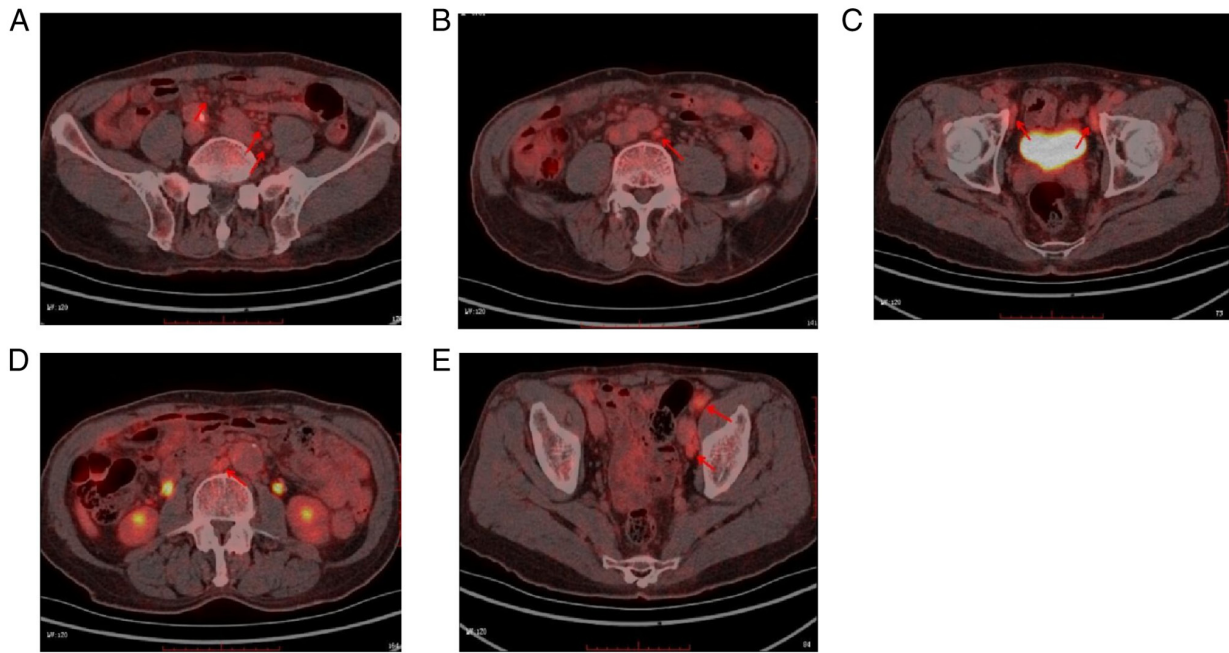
Whole body PET-CT. (A-E) PET-CT demonstrated abnormally increased ^{18}F -fluorodeoxyglucose metabolism in lymph nodes in numerous regions of the body, which was consistent with the metabolic changes in progressive disease stage after lymphoma treatment. PET-CT, positron emission tomography-computed tomography. (A) Pelvic plane (S2). (B) Abdominal plane (L1-L2). (C) Pelvic plane (S5). (D) Abdominal plane (L2-L3). (E) Pelvic plane (S4).
